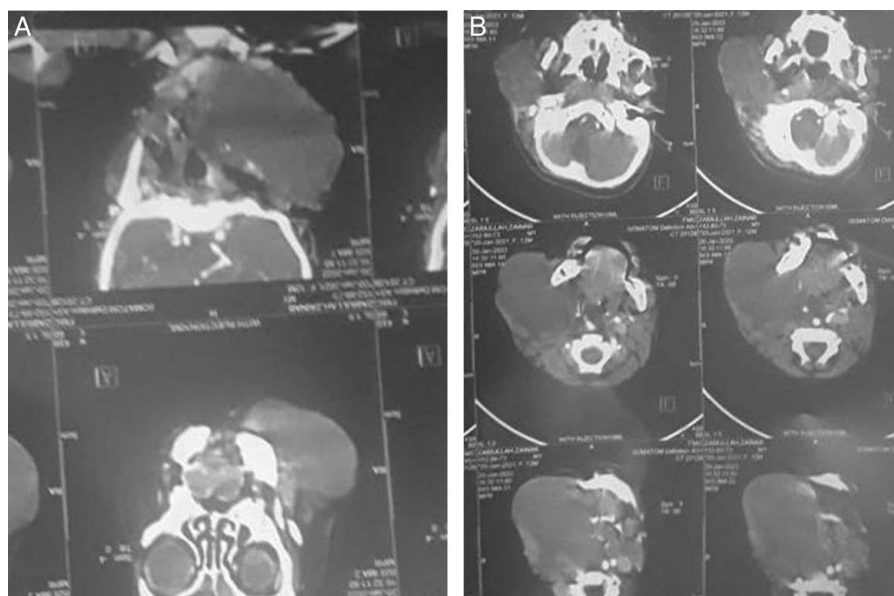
A and B: Computed tomography scan images of the lesion, revealing the cystic nature of the mass.
